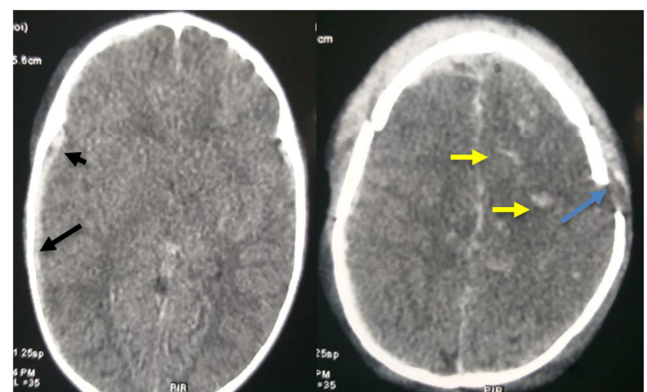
Preoperative brain CT, 9 month old child showing bilateral fronto-parietal contusions (Yellow arrow) with a left parietal fracture (Blue arrow) and an acute subdural hematoma (Black arrow).
